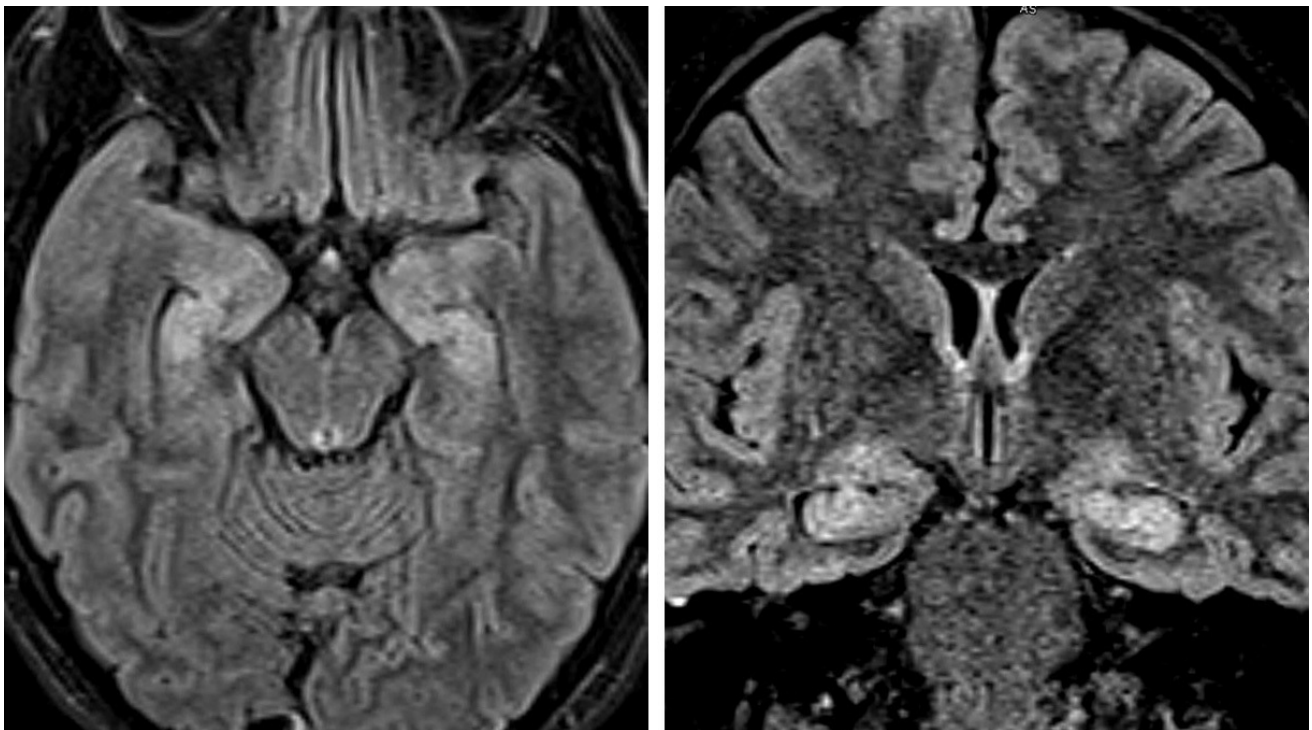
Axial (left) and coronal (right) FLAIR MR images demonstrate enlarged and hyperintense edematous hippocampi mimicking herpes encephalitis. In this patient, however, the findings were due to status epilepticus.
